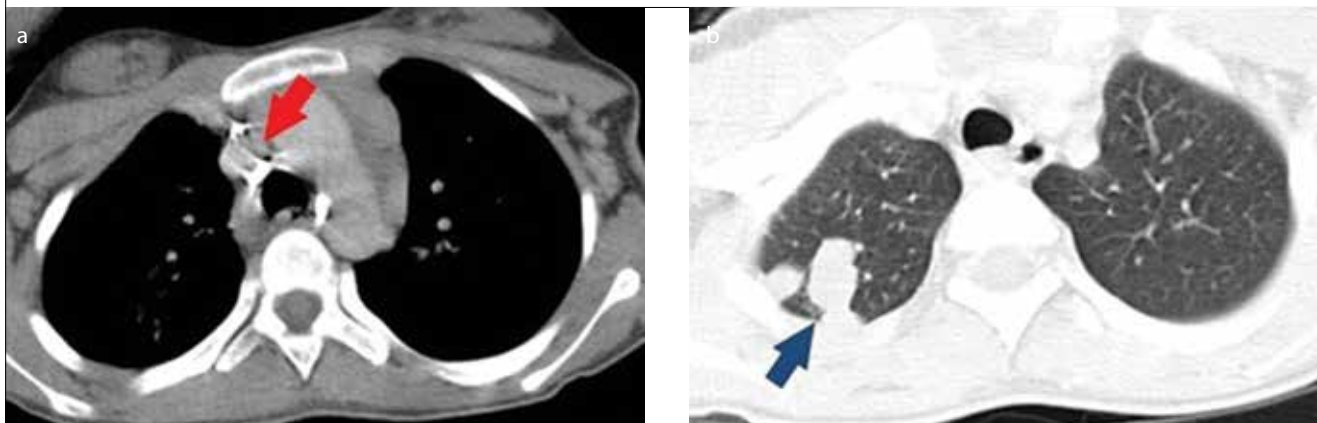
a, b. On thoracic CT, (a) there was a mediastinum window axial slice and calcified lymph nodes in the left paratracheal, pretracheal, and right hilum (red arrow), and (b) a parenchyma window axial slice and nodular lesions in the posterior of the right lung superior lobe (blue arrow)
